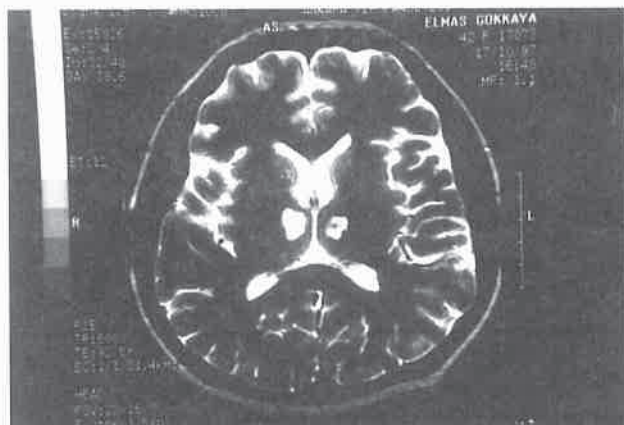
Bilateral anterior thalamic hyperintense lesions on T₂-weighted MRI compatible with ischemia.
